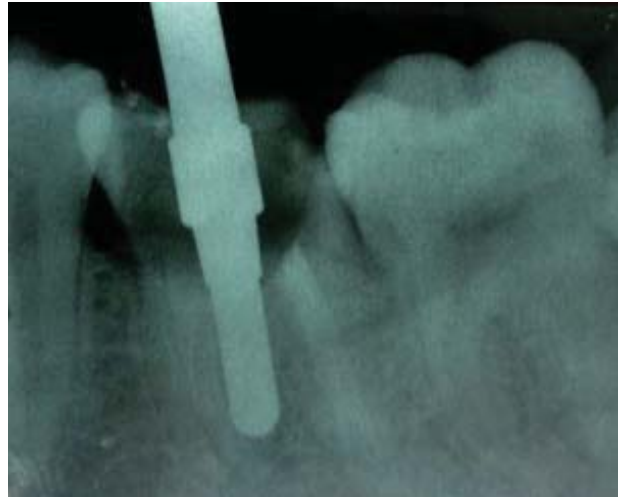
Radiograph with guiding pin
